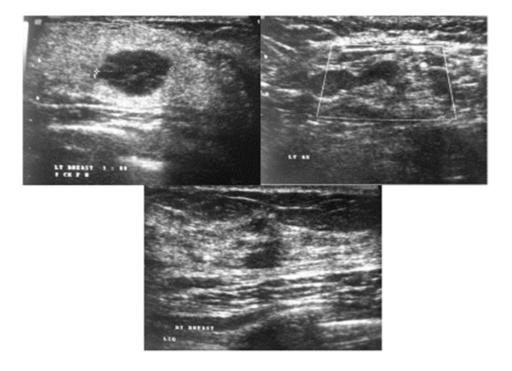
Ultrasound breast shows an ovoid hypoechoic lesion with slightly irregular margins in upper outer quadrant of left breast (a) with a similar smaller lesion in right breast (b). Enlarged left axillary node seen (c).
